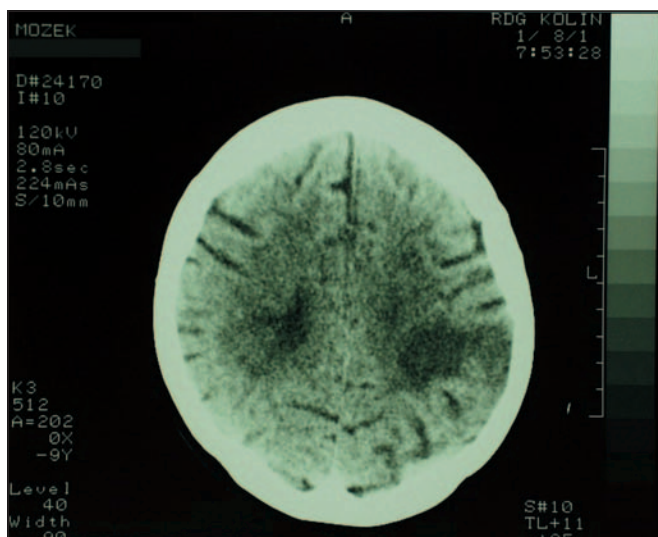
CT of the brain – malacic focus para-occipally in the left hemisphere
